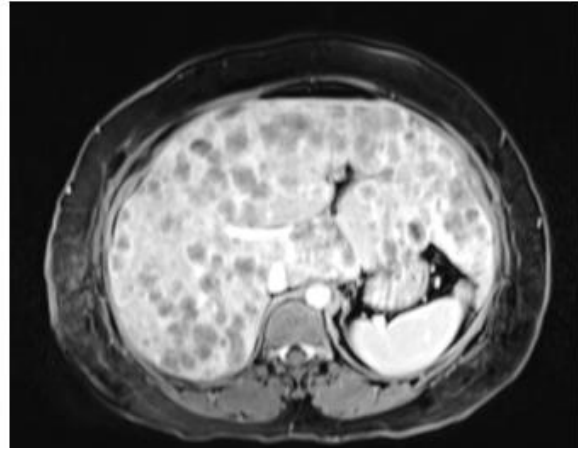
Contrast MRI- Multiple small well-defined lesions, T1 isotense/ T2 hyperintense with surrounding hypointense rim, peripheral enhancement on arterial and venous phase with relative washout on delayed phase
